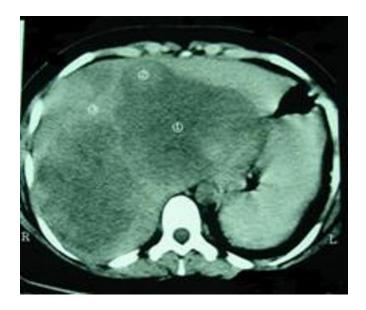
Computed Tomography (CT) scan of the giant hemangioma (one year before rupture)
